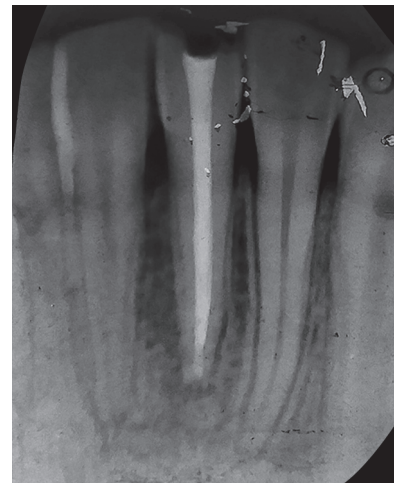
Marked reduction in size of the periapical lesion after therapy with Metapex
